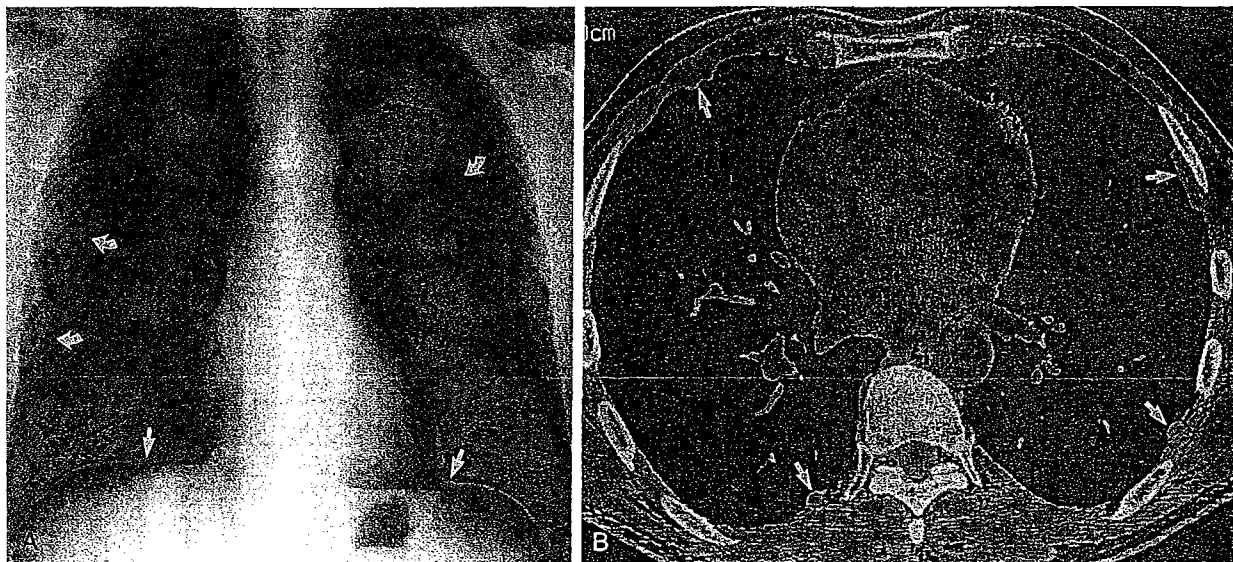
Pleural Plaques. A posteroanterior chest radiograph (A) demonstrates multiple pleural-based opacities along the chest wall and diaphragm. Several are viewed tangentially (straight arrows), whereas others are ill-defined because they are viewed *en face* (curved arrows), indicating their origin from the posterolateral or anterolateral chest wall. HRCT (B) confirms the presence of bilateral plaques (arrows). The patient was a 51-year-old shipyard worker.
